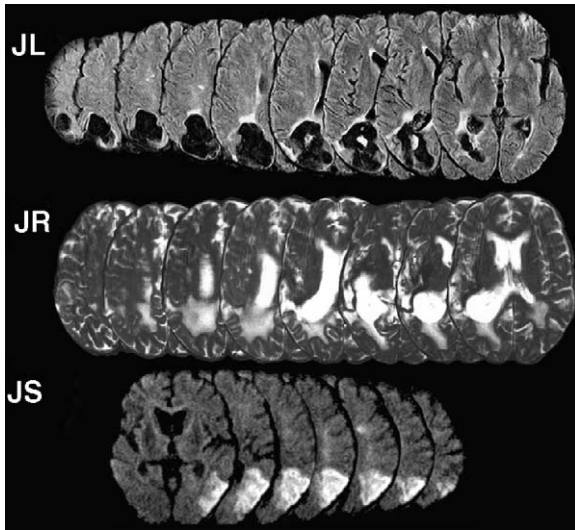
Horizontal MRI sections through the cerebral hemispheres of the three stroke patients with unilateral lesions are shown here. Flair images for JL and T2-weighted images for JR are reported. JL and JR had extensive lesions of the right lateral occipital, supramarginal, and angular gyri, as well as the precuneus and the superior parietal lobule. Pre-existing white matter lesions are also evident in JR. JS's diffusion weighted images are reported. He had an infarct of the left angular and supramarginal gyri.
